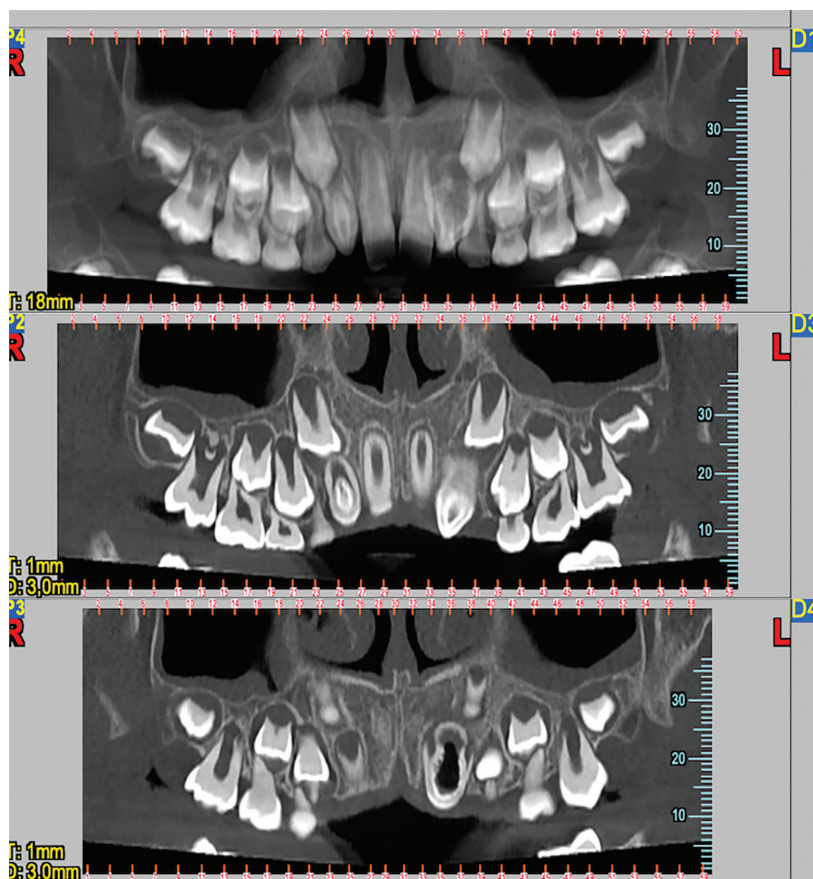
Second level X-ray
